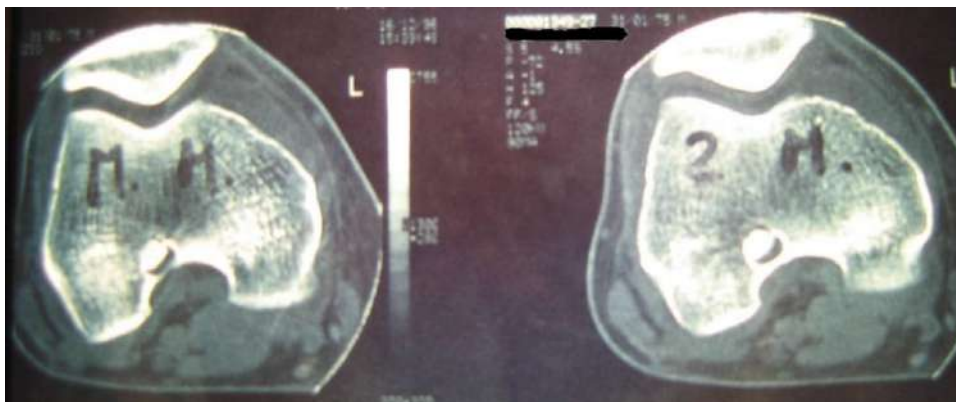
CT scan at 2 months follow-up.
